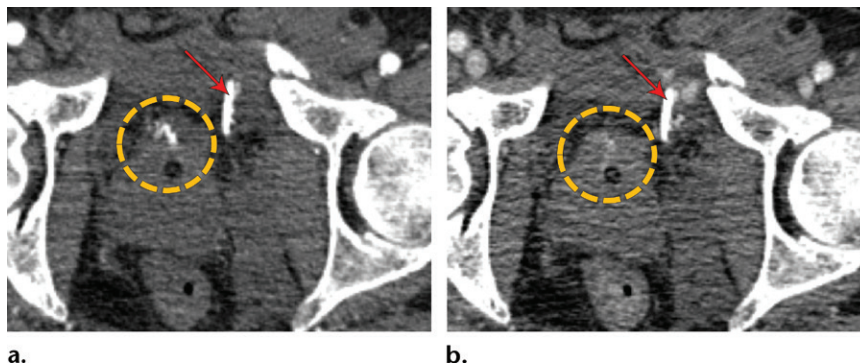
CT pitfall: retrograde urethrography in a 32-year-old man. Axial CT scan at the level of the pubic symphysis shows opacified urine outside the urinary bladder (arrows) after retrograde injection of contrast material through the urethral meatus. This finding can be misinterpreted as active contrast material extravasation.
